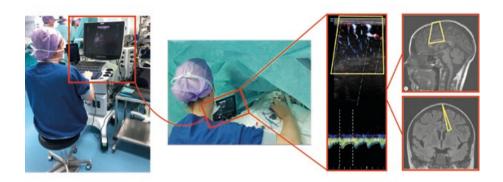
Ultrasound measurement setup. Left panel: One researcher controlled the ultrasound machine outside the workspace of the surgeon and anaesthesiologist. Middle: One researcher held the probe and performed the ultrasound scan with the feedback by an extended screen. Right panel: The cerebral vasculature in the ultrasound plane was visualized with power Doppler. The spectral Doppler gate was placed in a vertically oriented part of this pial artery.
